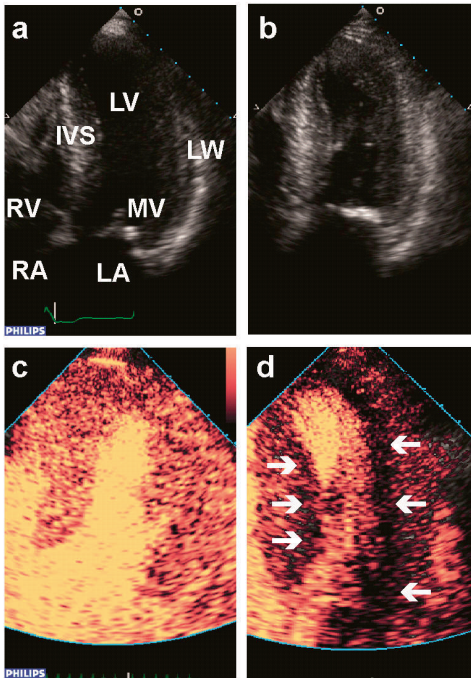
Apical 4-chamber ultrasound image of the heart for two patients with hypertrophic cardiomyopathy. Image a + b): without ultrasound contrast agent. Image c + d): corresponding images to a + b with ultrasound contrast agent. White arrows indicate perfusion defect. IVS = inter-ventricular septum, LA = left atrium, LV = left ventricle, LW = lateral wall, MV = mitral valve, RA = right atrium, RV = right ventricle. Images courtesy of Dr. O.I.I. Soliman and Dr. F.J. ten Cate, Thoraxcenter, Erasmus MC, Rotterdam, the Netherlands.
